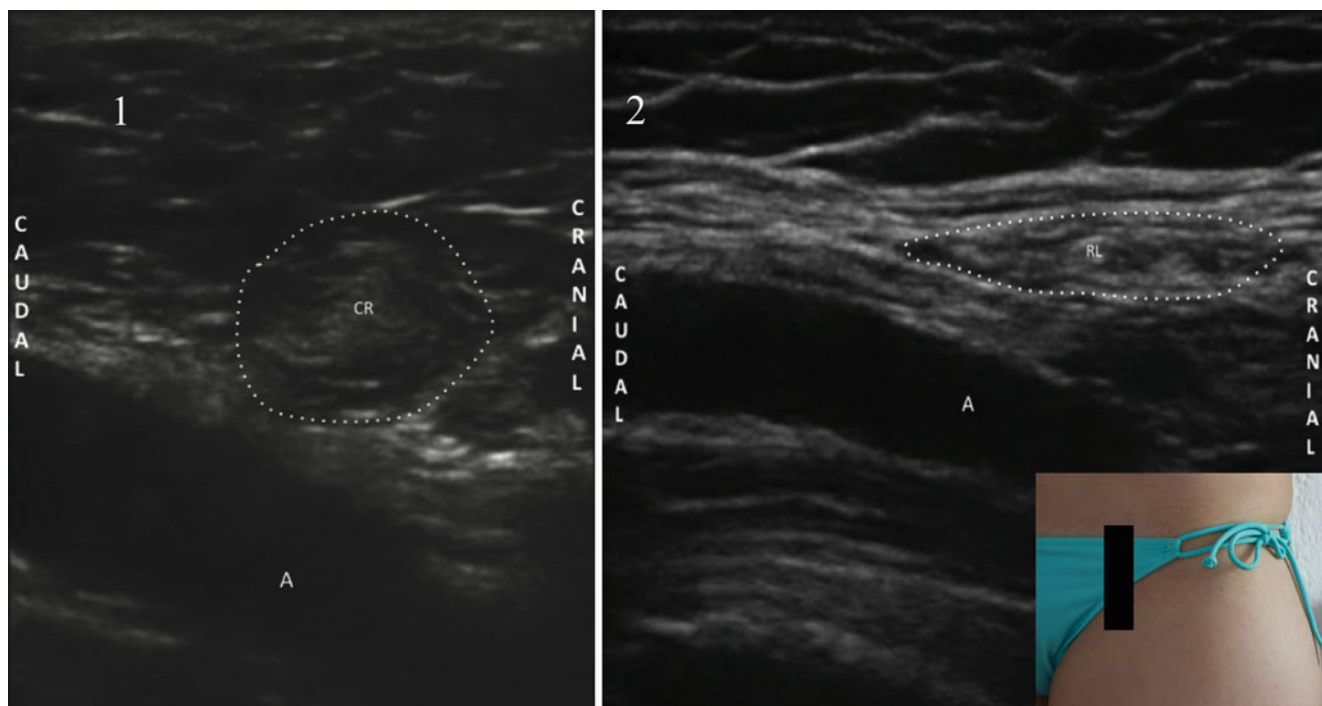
Genitofemoral ultrasound imaging. 1 Cross-sectional ultrasound image of the male internal inguinal ring. *Dotted line* represents the internal inguinal ring; *CR* cremaster, *A* external iliac artery. 2 Cross-sectional ultrasound image of the female internal
